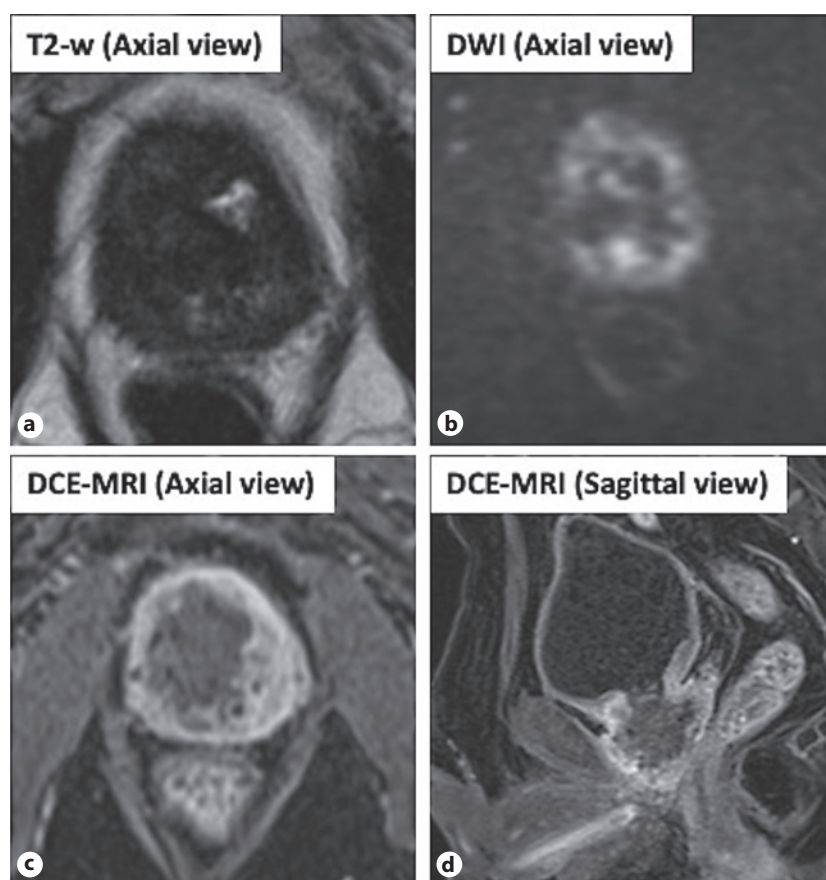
Prebiopsy MRI showed that the entire prostate was occupied by lesions with strong hypointensity on T2-weighted images (a), obscuring the normal prostatic urethra. Diffusion-weighted (b) and dynamic contrast-enhanced MRI (c, d) showed peripheral hyperintense and central hypointense appearance. Sagittal images (d) showed that the tumor extended directly to the dorsal cortex of the pubis. These findings suggested an infiltrative malignant tumor with internal necrosis (PI-RADS 5).
